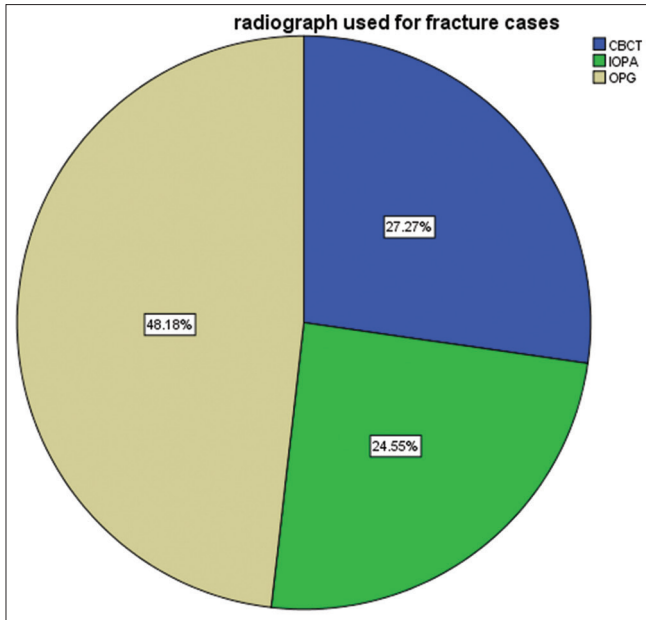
That where radiographs used
